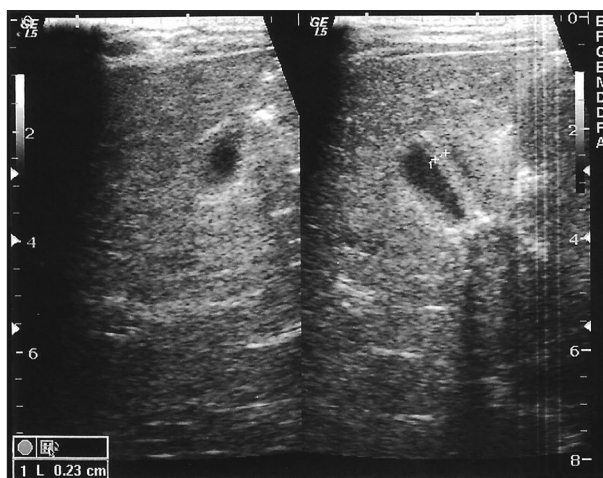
Sonogram, showing thickening of the gallbladders in patients that had ileal resections (limited resection and right hemicolectomy)
